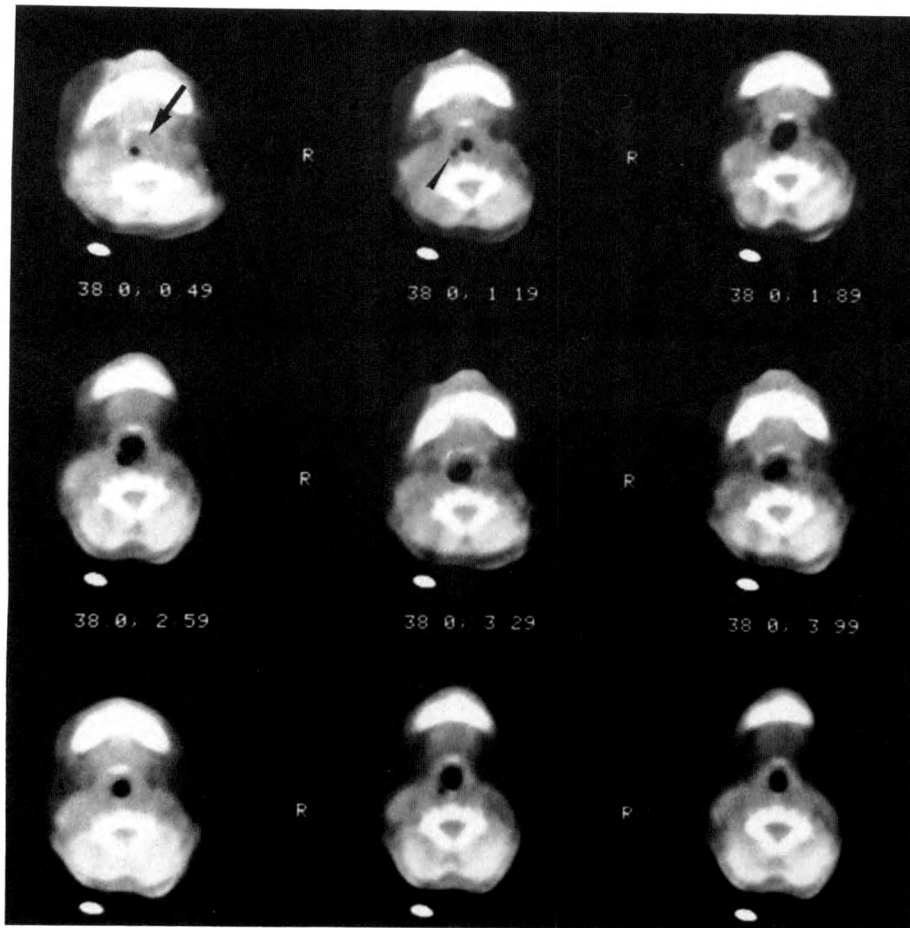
Laryngomalacia. Cine-CT examination of 6-month-old child with stridor shows complete collapse of laryngeal airway during quiet breathing (arrow). Air is seen within right pyriform sinus (arrowhead). Laryngomalacia was confirmed by endoscopy. (Read images from left to right.)
